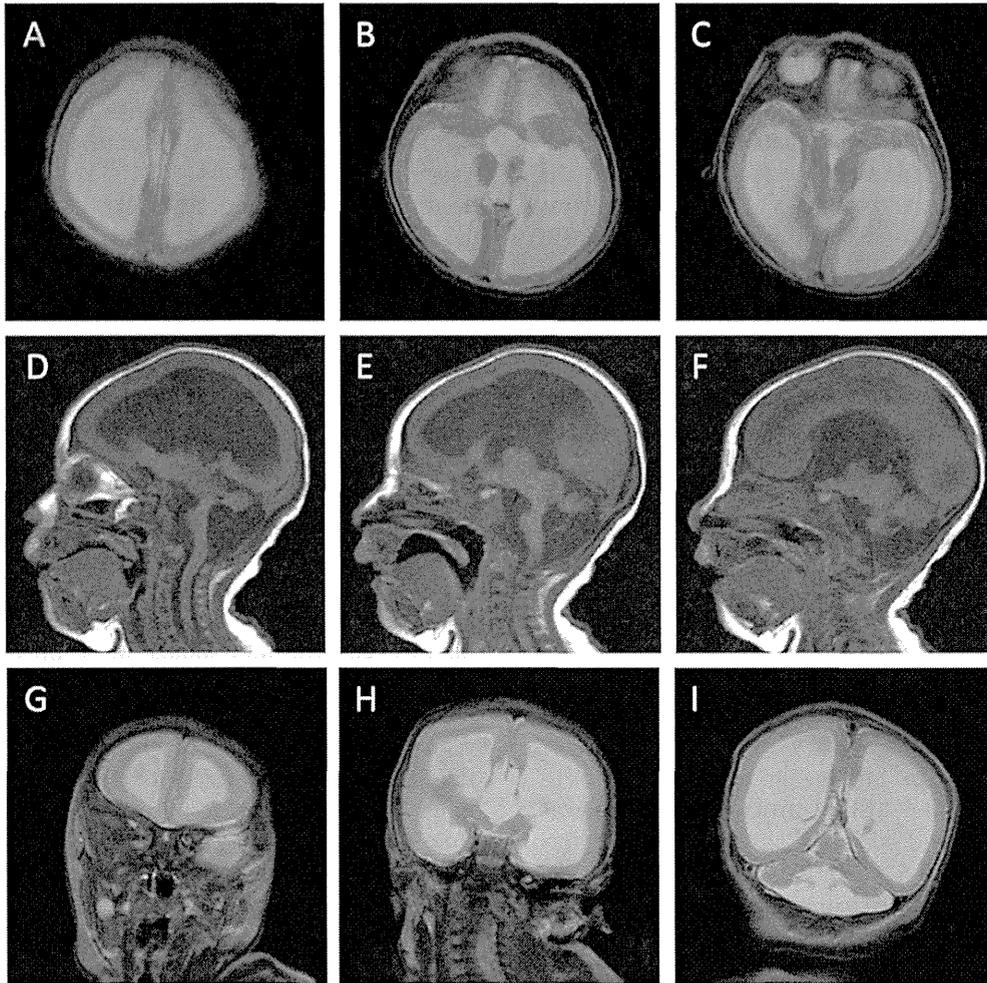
T2 weighted Axial (A, B and C), T1 weighted sagittal (D, E and F) and T2 weighted coronal (G, H and I) images by MRI showing agyria (grade I) (A-I), agenesis of the corpus callosum (D-F, H), excessive dilation of lateral ventricles (A, B, C, D, G, H, I), abnormal rotation of hippocampus (H), the basal ganglia and thalamus of the dysmorphic and hypoplastic features (B, H), cerebral aqueduct stenosis (E), cerebellum posterior rotation, and pontocerebellar hypoplasia (D, E, F, I).
